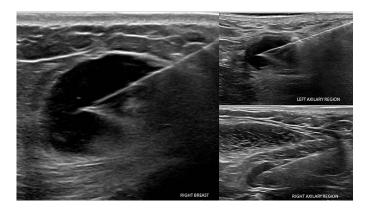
Images of ultrasound-guided biopsy of the mass localized in the right breast and lymph nodes of right and left axillary region.
